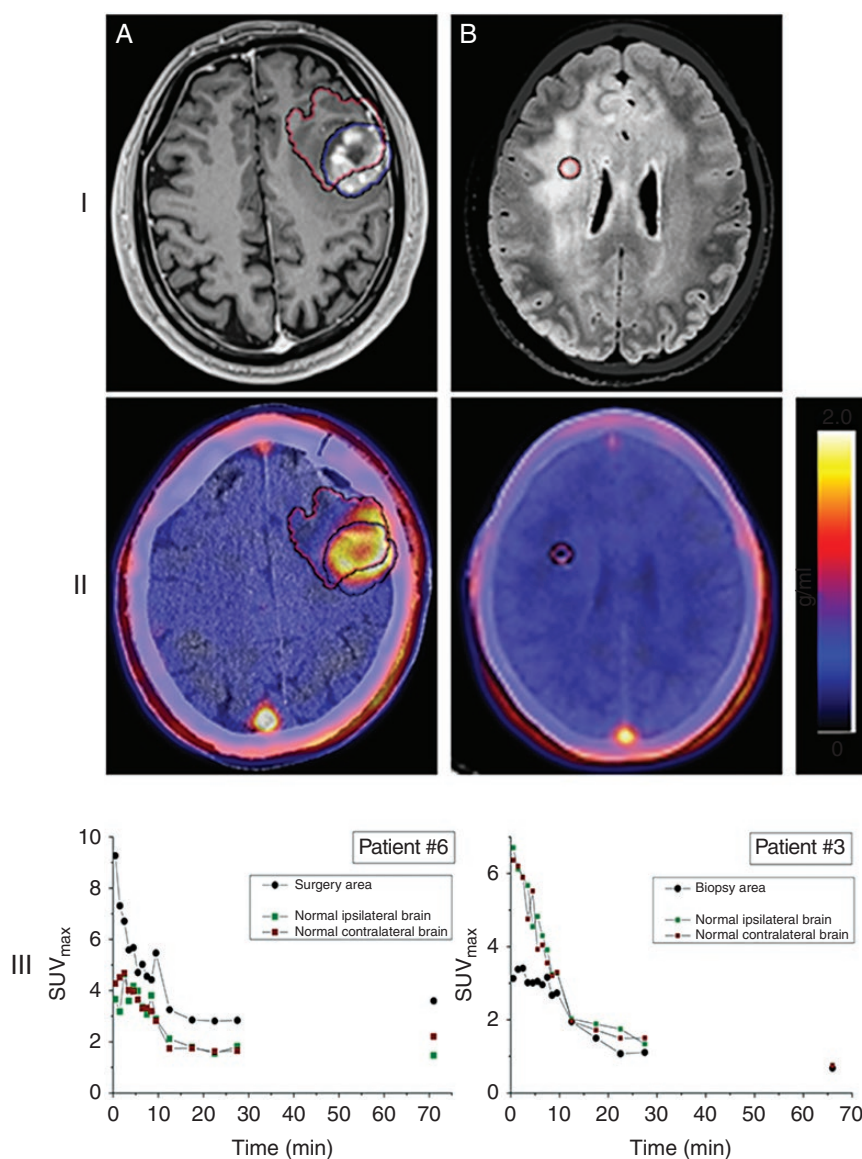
[¹⁸F]-FDHT uptake in high-grade gliomas. (I) MRI and (II) PET (registered with post-op CT/MRI) transaxial slices showing (A) high (patient #6), and (B) no (patient #3, gliomatosis cerebri) [¹⁸F]-FDHT uptake on static PET images acquired about 60 min after radiopharmaceutical injection. Blue and red VOIs represent respectively the tumor and biopsy/surgery area on MRI and PET slices. (III) Time-activity curves in terms of SUV_{max} corresponding to the biopsy/surgery area and normal ipsi- and contralateral brain. The color scale next to each PET image represents the SUV in units of g/mL.
